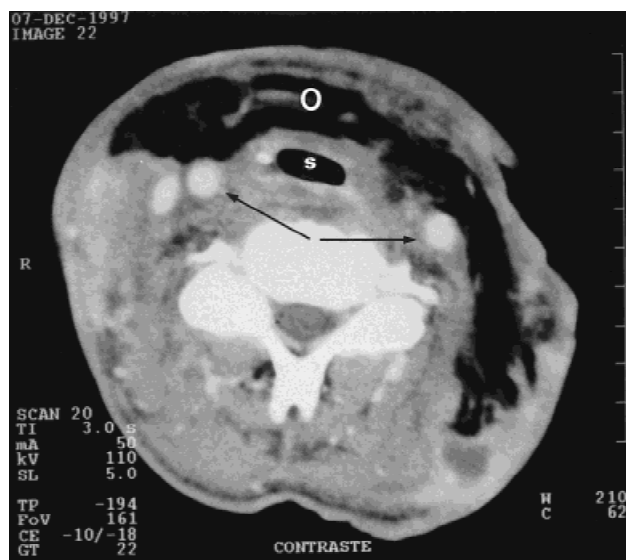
CT of transferred omentum protecting carotid/innominate arteries showing omentum (O), carotid arteries (arrows), and stomach lumen (S).
